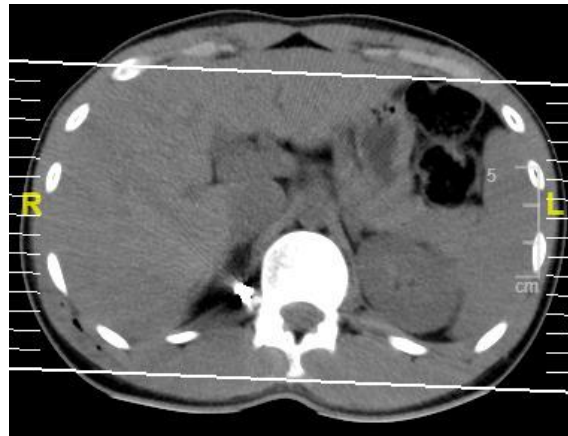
CT scan of thoracic vertebrae region
